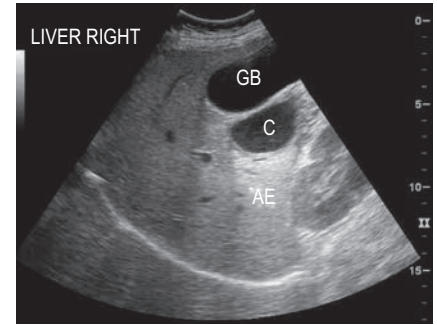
Acoustic Enhancement from Fluid-filled Structures. Acoustic enhancement is seen where the ultrasound beam passes through the gallbladder and more prominently where it passes through the gallbladder and pancreatic pseudocyst. AE, Acoustic enhancement; C, pancreatic pseudocyst; GB, gallbladder.
